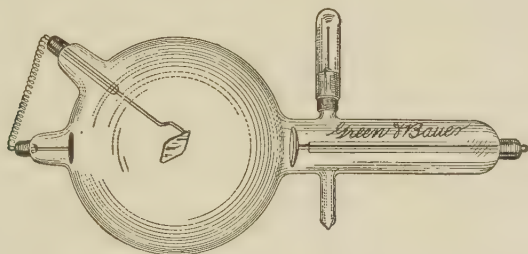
Roentgen Ray Tube with Light Anode, for Static Machine.
